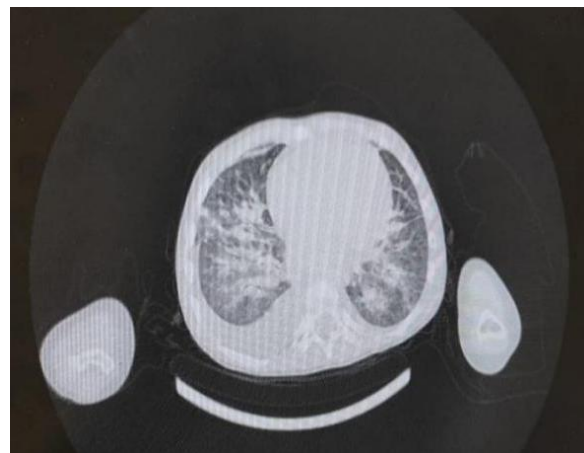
The lung high-resolution computed tomography scan shows increased peribronchovascular interstitial thickening with pleural effusion.
